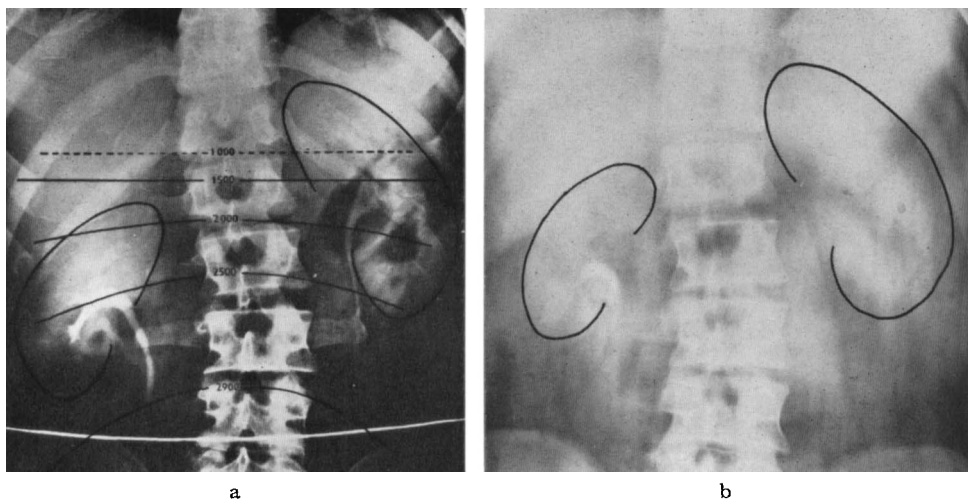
Renal outlines in a patient: a) 1952 before roentgen therapy, and b) four years later. The right kidney is low-lying.
